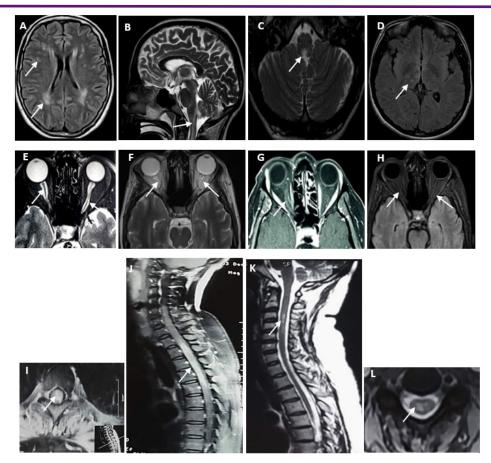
MRI findings of six NMOSD patients. A, B, C: Brain MRI of a patient with AQP4+ NMOSD and area postrema syndrome demonstrating bilateral subcortical and deep white matter lesions on axial fluid-attenuated inversion recovery (FLAIR) MRI (A) and T2 hyperintensity in the dorsal medulla on T2 weighted brain sagittal MRI (D) with typical symmetrical ependymal lesion around the periaqueductal area on T2 weighted brain axial MRI (C). D: Axial fluid-attenuated inversion recovery (FLAIR) MRI of a patient with AQP4+ NMOSD showing lesions involving the thalamus and the hypothalamus. E, F, G: T2 weighted orbital axial (E) and Short Tau Inversion Recovery (STIR) (F) MRI of a patient with AQP4+ NMOSD and retrobulbar optic neuritis showing bilateral increased T2 and STIR signals within optic nerves with gadolinium enhancement (G). H: Orbital axial FLAIR MRI of a patient with AQP4+ NMOSD and recurrent retrobulbar optic neuritis demonstrating bilateral optic nerve atrophy. I, J: Spine sagittal (I) and axial (J) FLAIR MRI of a patient with AQP4+ NMOSD presenting with spastic paraplegia and urinary retention showing longitudinally extensive myelitis from C5 to D8. K, L: Spine sagittal (K) and axial (L) T2 weighted MRI of a patient with AQP4+ NMOSD presenting only with retrobulbar optic neuritis showing central medullar non-extensive myelitis.
